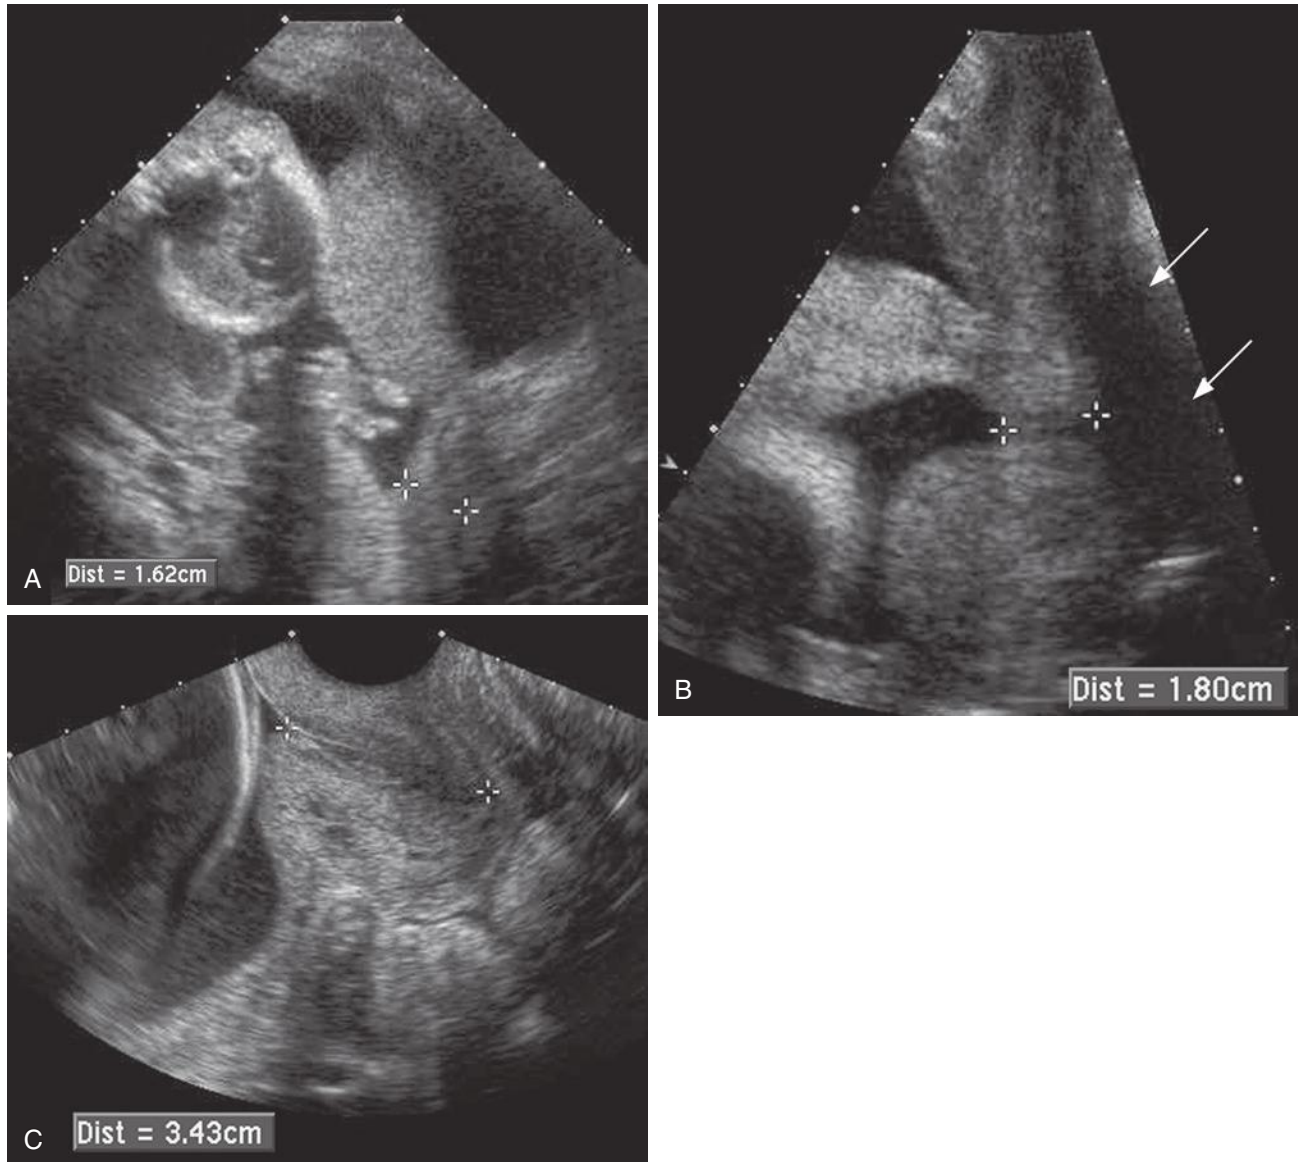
Three methods of imaging the cervix. A, Transabdominal sonogram. The cervix, which is distant from the ultrasound transducer, is poorly seen and appears to measure 1.62 cm in length (*calipers*). B, Translabial sonogram in the same patient. With this approach, visualization of the cervix is somewhat clearer, but shadowing from air in the rectum (*arrows*) partially obscures the view, resulting in undermeasurement of the cervical length (*calipers*). C, Transvaginal sonogram. The cervix is well seen and measures 3.43 cm in length (*calipers*).
